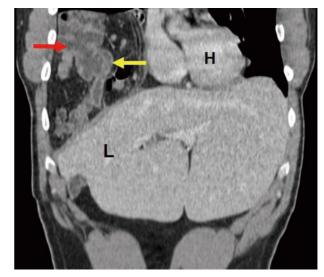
Coronal CT scan shows elevation of the cecum (red arrow) and terminal ileum (yellow arrow) to the right infradiaphragmatic region above the liver. L: Liver; H: Heart.
